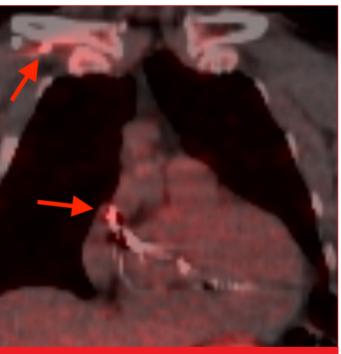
Positive PET/CT. Positive PET/CT examination showing the involvement of the leads with 18-FDG
